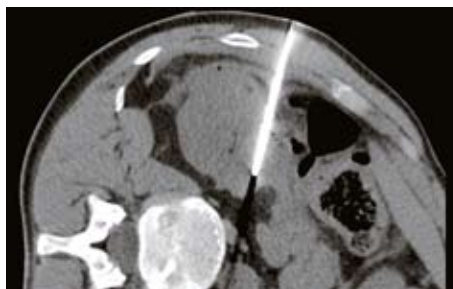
The CT scan confirmed the appropriate placement of the electrode and the presence of a safe distance to the bowel.
